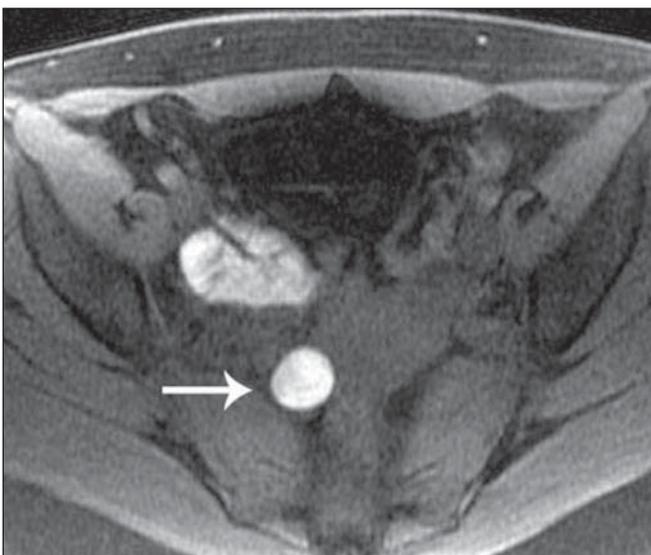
Endometrioma. Axial MRI T1-weighted fat-sat image acquired with a 1.5 T scanner, demonstrating a focus of hypersignal intensity on the right ovary.
